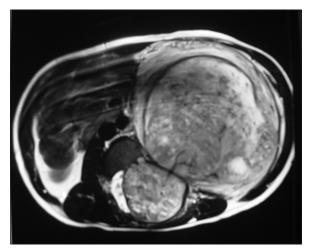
Magnetic resonance imaging scan showing a "dumbbell" spinal neurofibroma, with large with the extraspinal part being larger than the intraspinal portion
